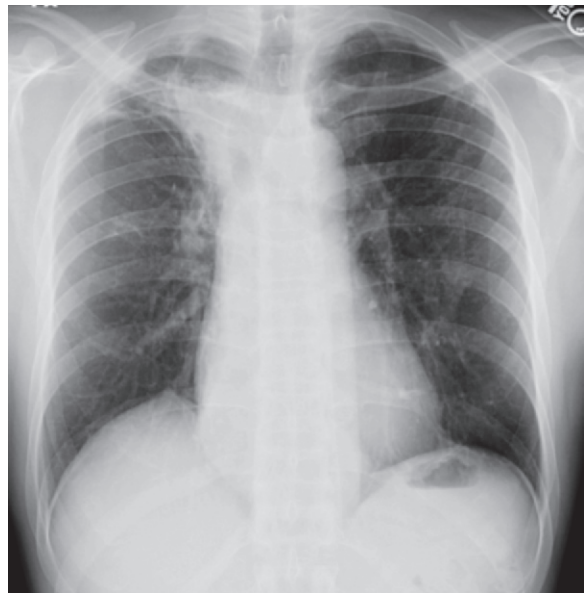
Scarring from reactivation tuberculosis in a patient with HIV infection. Chest radiograph shows scarring and volume loss caused by reactivation tuberculosis in the right upper lobe.
